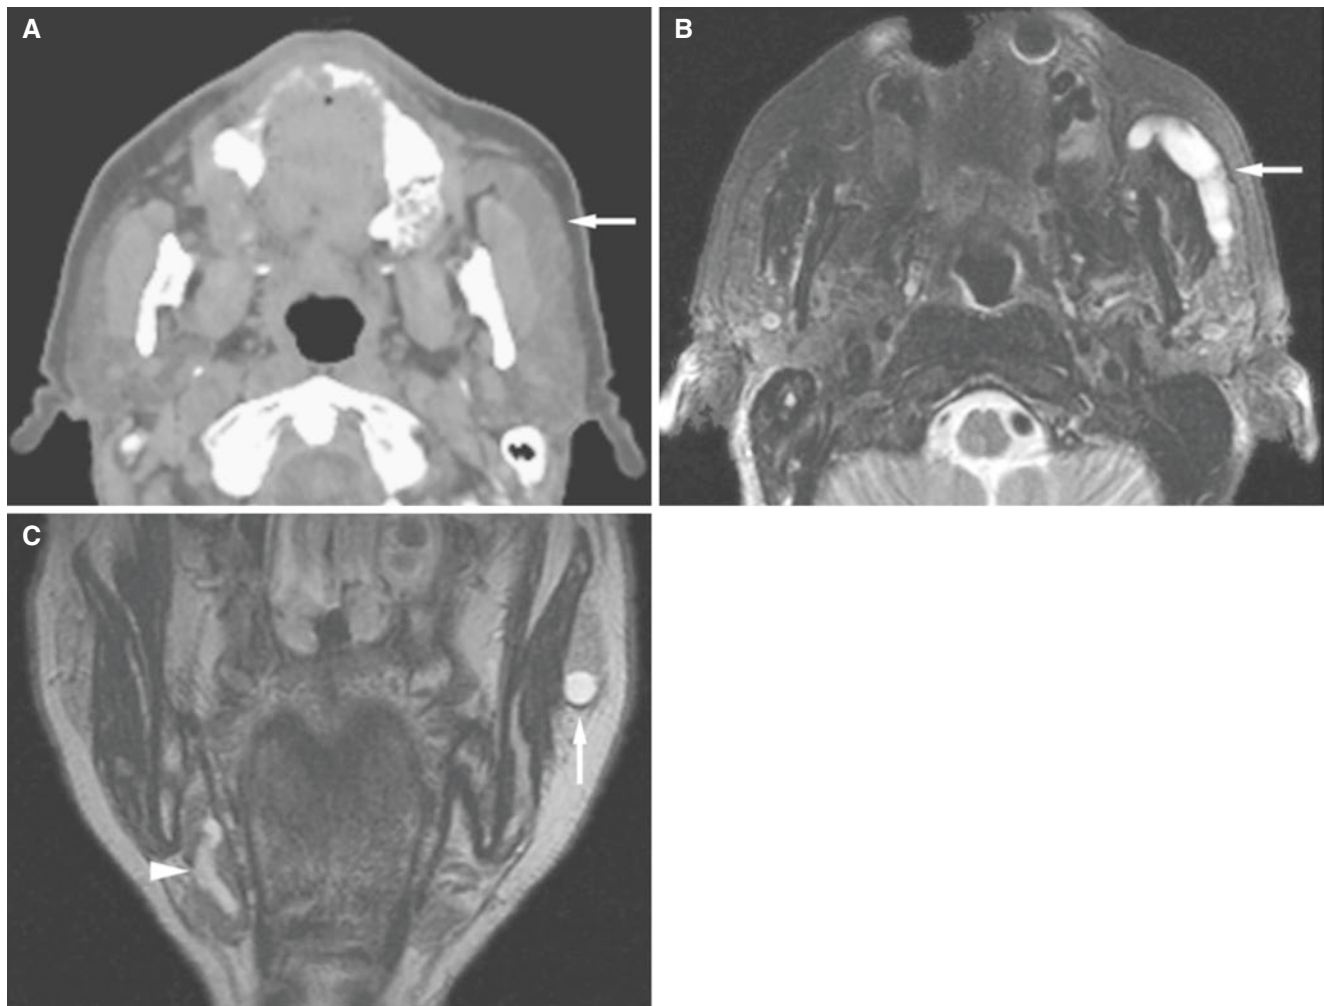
Dilated Stensen's duct and Wharton's duct; 76-year-old male with enlarged right submandibular salivary gland and question of possible tumor (no calculi or gland abnormalities except slightly enlarged right submandibular gland found on CT and MRI imaging).
